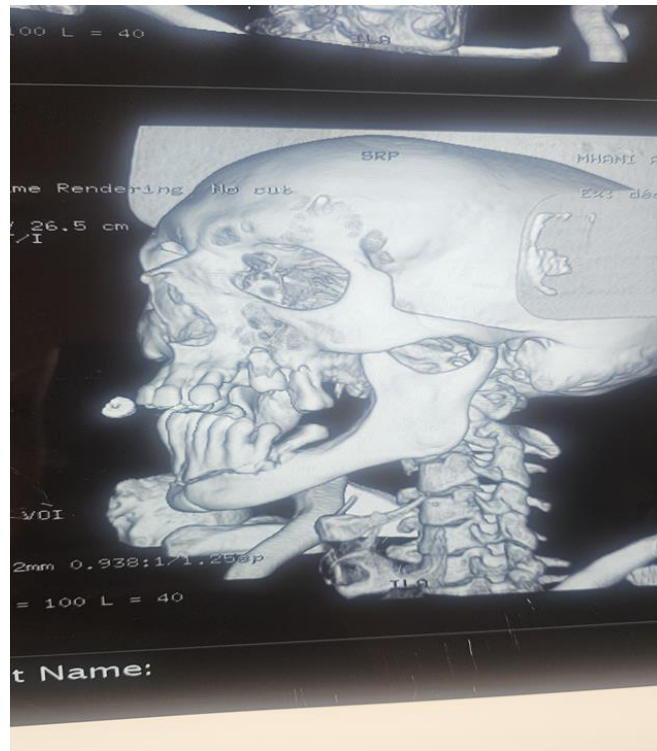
CT scan of the head, 3D view showing comminuted horizontal anterior fracture of mandible body
